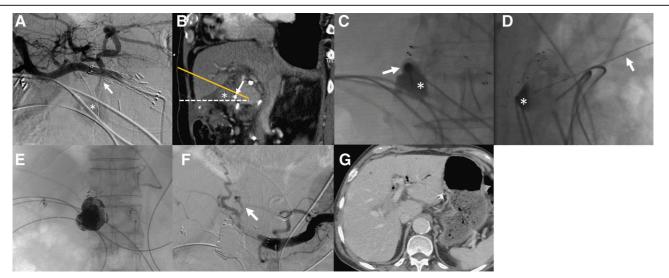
A 72-y-old man with adenocarcinoma of the pancreatic head underwent pancreaticoduodenectomy. Gastroduodenal artery stump bleeding occurred 25 d after surgery. Covered stent placement was initially performed, and a follow-up diagnostic angiography was done. A, Rebleeding with pseudoaneurysm (asterisk) due to type I endoleak from the distal left hepatic artery (arrow) was noted on the follow-up angiography. To seal the stent with balloon was tried; however, postdilatation arterial dissection was noted during the procedure. To avoid additional complications, direct puncture was performed instead of transcatheter therapy. B, The optimal gantry and puncture angle (solid line) were calculated relative to the anterior-posterior angle (dashed line) on a sagital computed tomography (CT) slice to prevent injury to the jejunum (asterisk). One of the drainage tubes (arrow) was used as a landmark for direct puncture. C and D, Frontal and lateral biplane observation with contrast injection confirmed the location of the needle tip (arrow) in the aneurysmal sac (asterisk). E, After coil and n-butyl cyanoacrylate glue embolization, a follow-up celiac angiography revealed occlusion of the hepatic artery. F, Delayed opacification of the left hepatic artery from collaterals of the proximal left hepatic artery was observed (arrow). G, Follow-up dynamic CT one month after embolization revealed no ischemic change in the liver parenchyma.
